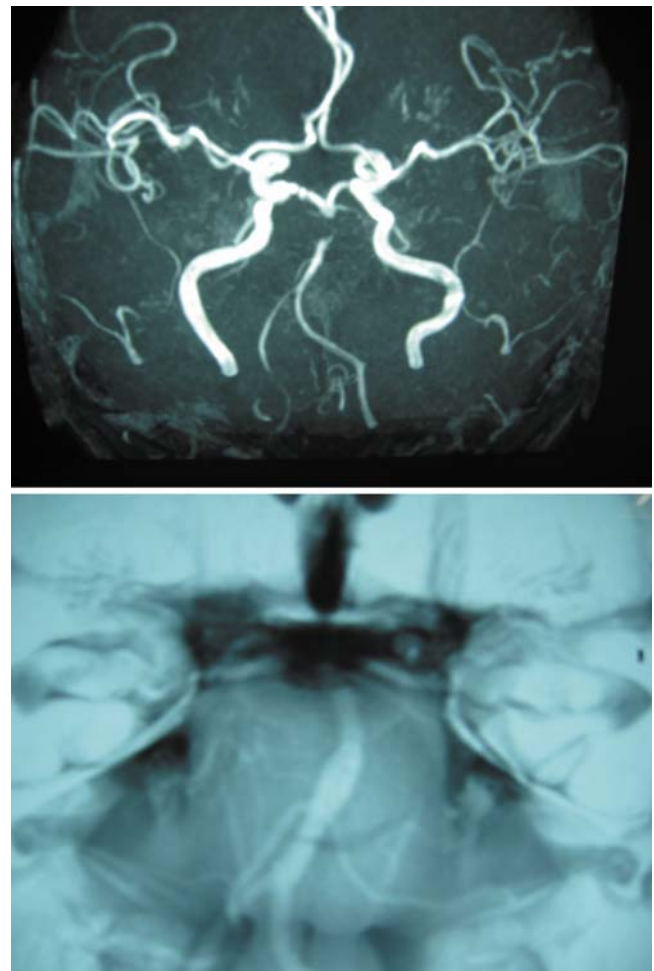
Forty-nine-year-old female with transient right hemiparesis. She had had no headache. A high-intensity area was noted in the basilar artery on T1 image (*upper left*). MRA revealed occlusion of the upper basilar artery (*upper right*). Angiography revealed pearl-and-string sign on the basilar artery (*lower left*), the outer appearance of which was a sausage-like swelling on BPAS-MR imaging (*lower right*)
